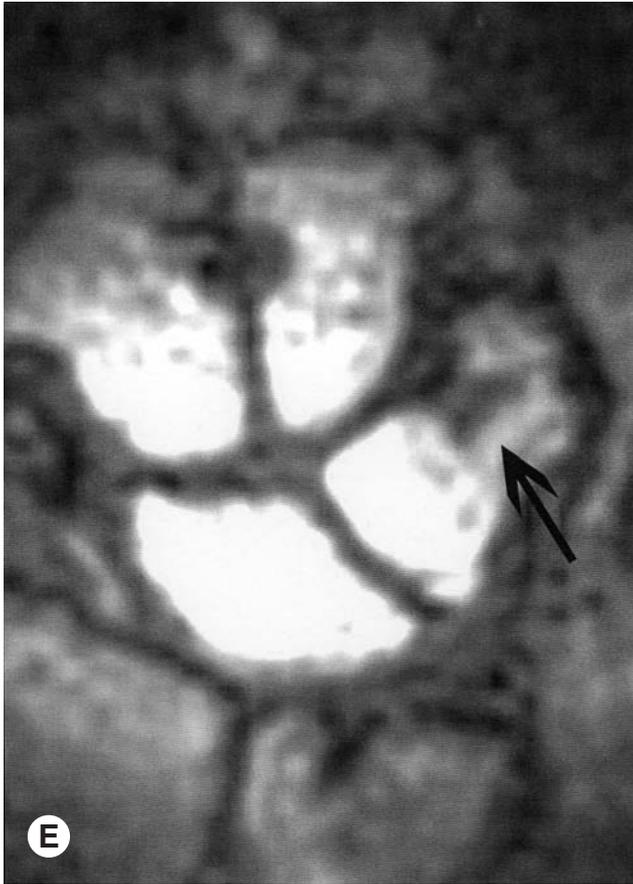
Simultaneous progression and regression of erosions. A. This T1-weighted coronal image shows a subchondral marginal erosion involving the radial aspect of the third MC head (arrow). The patient was given MTX and a TNF- $\alpha$  inhibitor. B. After 6 months on therapy the subchondral lesion markedly improved (arrow). C. Continued improvement is seen after 11 months (arrow). D. The wrist images on the same patient showed an erosion of the distal triquetrum (arrow) at diagnosis. The signal changes in the hamate and capitate are normal ligament insertion sites (small arrows). E. Increase in the size of the distal triquetral erosion is evident after 6 months of treatment (arrow) in the same time interval during which the MCP lesion in panel B decreased in size. F. The distal triquetral erosion decreased in size during the additional 5 months of therapy (arrow).
